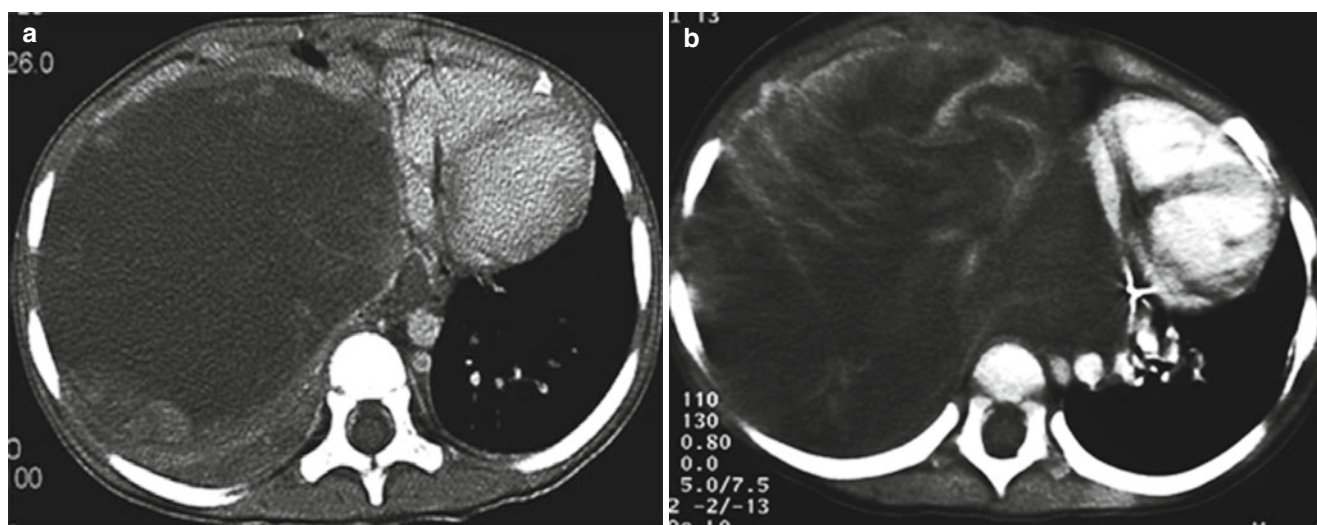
Pleuropulmonary blastoma in a 2-year-old girl. (a, b) Nonenhanced (a) and contrast-enhanced (b) CT show a large, predominantly low-attenuation mass with whorls of high-attenuation soft tissue filling the right thorax and displacing the mediastinal contents
